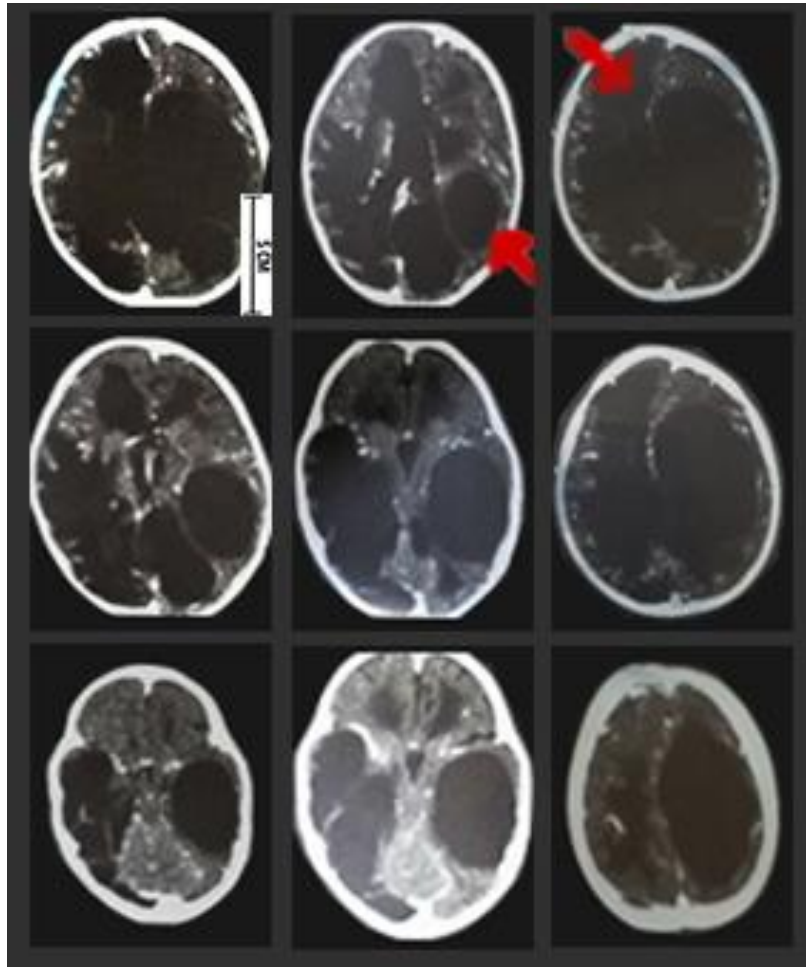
Cerebral Computerized Tomography (CT) with contrast, indicating multiloculated pediatric hydrocephalus. The image was performed after 4 weeks of antibiotics and external shunt. The red arrows point to multiple cysts.
